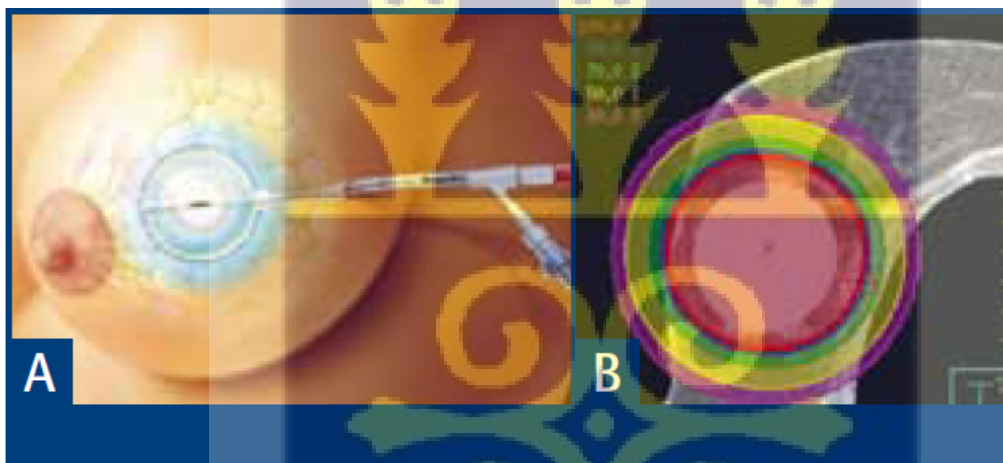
Intracavitary balloon brachytherapy. A: Presentation of the Mammosite® catheter. B: Transversal CT slice with an indication of the isodoses (view colour code). Note the 100% isodose reaching the skin (Erven *et al.*, 2008).
